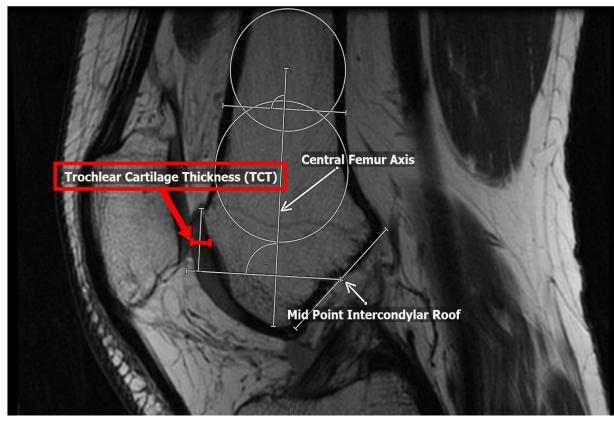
Left Knee MRI demonstrating position of Central Femur Axis, Mid-Point of the Intercondylar Roof, and method to find Trochlear Cartilage thickness (TCT) at the mid-point of the trochlear length.
